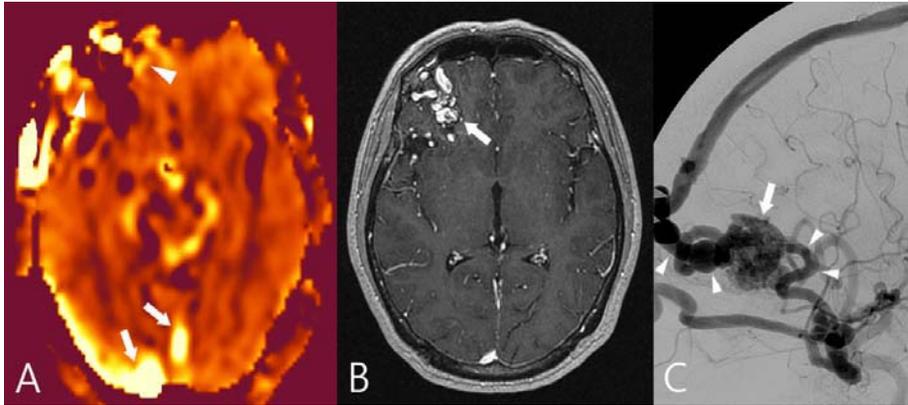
A 52-year-old female who presented with headache. (A) Axial arterial spin labeling (ASL) image shows multiple high signal intensity foci (arrowheads) adjacent to large signal void area in the right frontal lobe. One of the reviewers regarded these hyperintense foci as negative because he thought they were symmetric to the signal in the contralateral frontal lobe. The image also shows intense signal intensity in the right transverse sinus and straight sinus (arrows). After discussion, the reviewers agreed that the high signal foci in the right frontal lobe represents a nidus signal. (B) Axial T1-weighted post-contrast image shows multiple tubular enhancing structures in the right frontal lobe (arrow). They represent a nidus with dilated veins. (C) Lateral digital subtraction angiography (DSA) confirms a frontal arteriovenous malformation (AVM, arrow) fed by frontopolar arteries originating from the right middle cerebral artery (MCA), with dilated venous structures (arrowheads) draining into the superior sagittal sinus and cavernous sinus.
